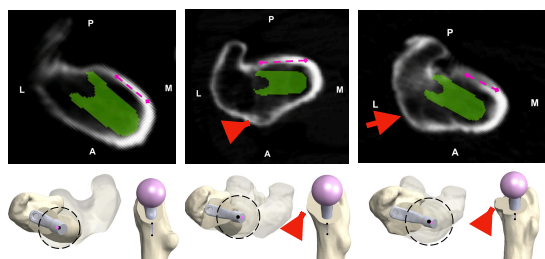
Case examples showing axial CT scan slices (at planned femoral neck osteotomy), corresponding 3D reconstructions (red arrows indicate anterior femoral neck osteophyte):
